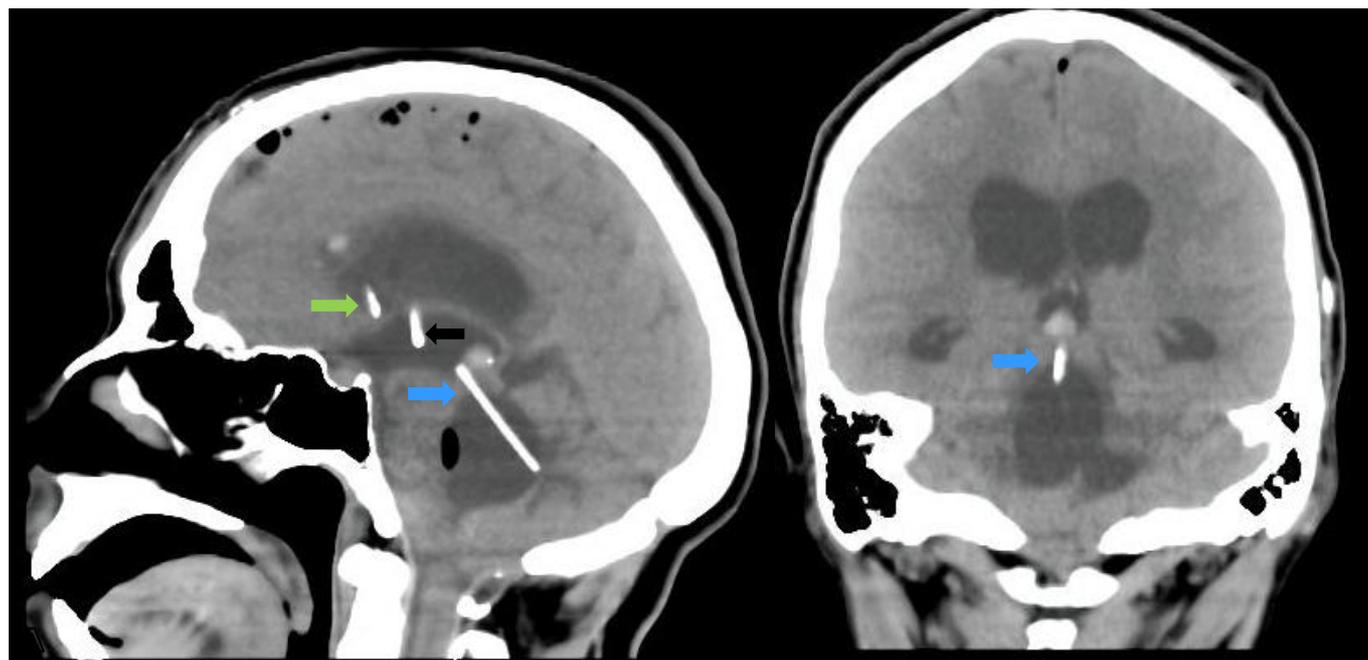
Cerebral CT scan without contrast in sagittal section (A) and in coronal section (B) in the immediate postoperative period, where Stent is observed in Sylvian aqueduct in proper position (light blue arrow) and slight decrease in hydrocephalus, as well as ventricular catheter in front horn (green arrow). End of old proximal catheter can also be seen in non-functioning III ventricle (black arrow)
